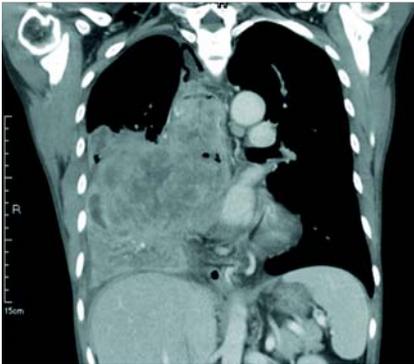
Chest computed tomography (CT) scan showing a huge heterogeneous mass arising from the reconstructed esophagus and directly invading the middle and lower lobes of the right lung, causing passive atelectasis. The bronchus intermedius also appears compressed by the mass.
